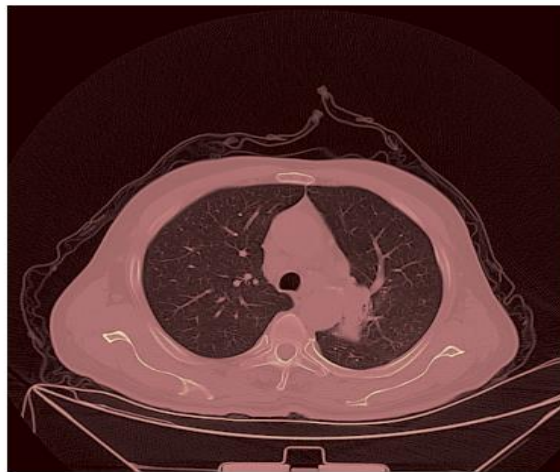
A CT scan image after applied HU transformation.
